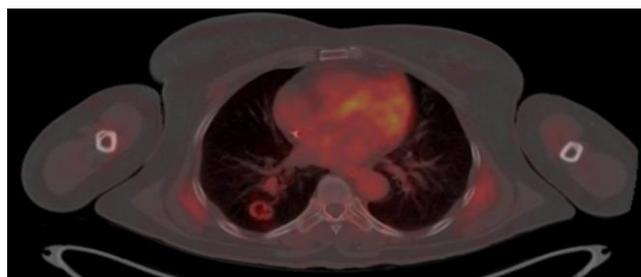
PET-CT showing metastatic cavitary lesion in right hemithorax
